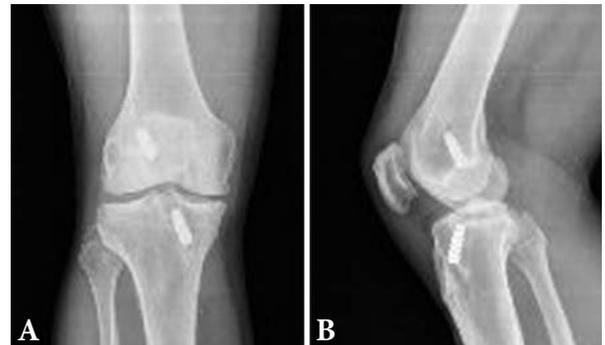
3AB. Profile and AP radiograph of the patient No. 6 after two years. Fracture of the patella treated non-operatively, only with plaster immobilization, is repaired, but there are steps on the articular surface.
